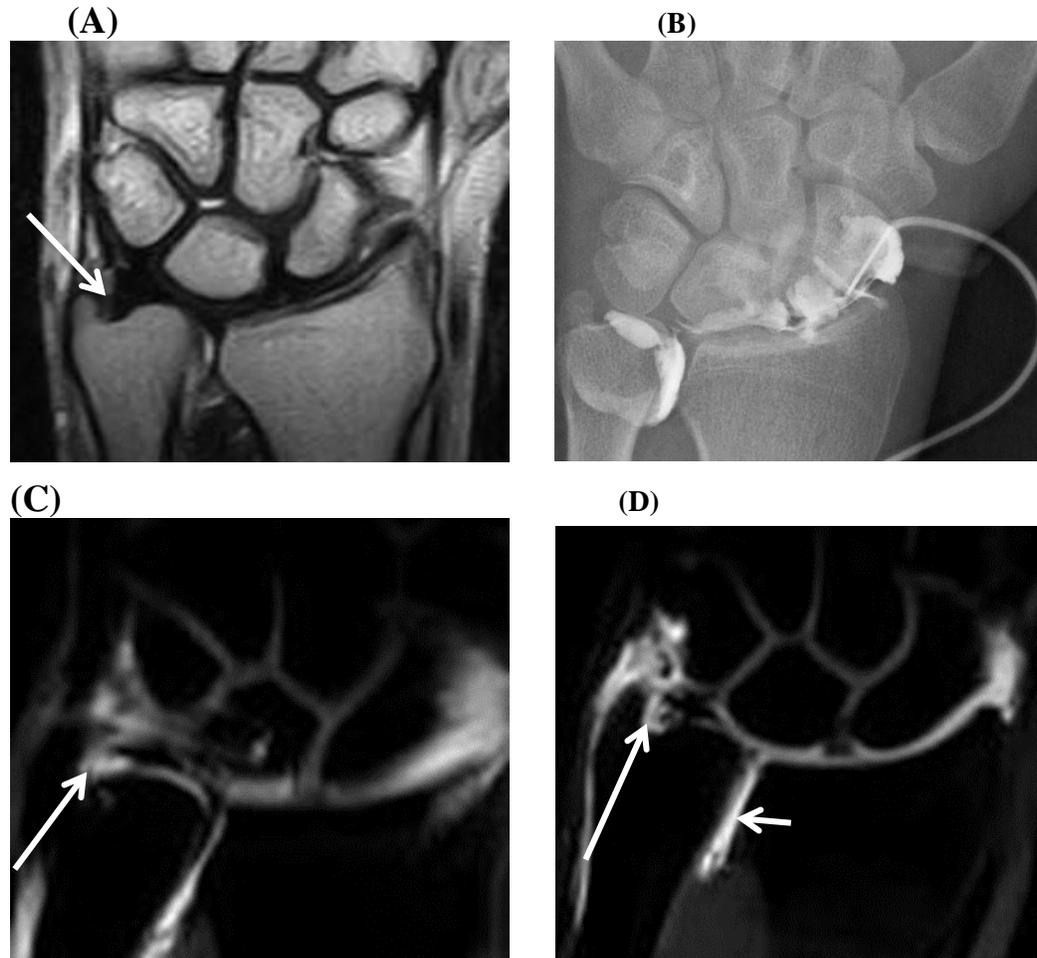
Case 1: Male patient 36 years old complaining of right sided ulnar wrist pain, he had history of fall in the right hand during playing football. Conventional MRI was done; (A): coronal T2 WI image: suggest detachment of the peripheral attachment of the TFCC to the ulna (arrow). (B): Radiocarpal injection with leakage of contrast in the distal radio ulnar joint (DRUJ) denoting underlying TFC tear. coronal T1 fat suppression MR arthrographic images (C) & (D) revealed: avulsion of the TFCC at the fovea attachment to the ulnar (arrow) with extension of the contrast to the distal radioulnar joint (short arrow), contrast extending in the soft tissue along the medial aspect of distal ulna suggestive of injury to the ulnar collateral ligament. Arthroscopy confirmed the MRA findings with peripheral (ulnar) TFCC tear class I-B.
